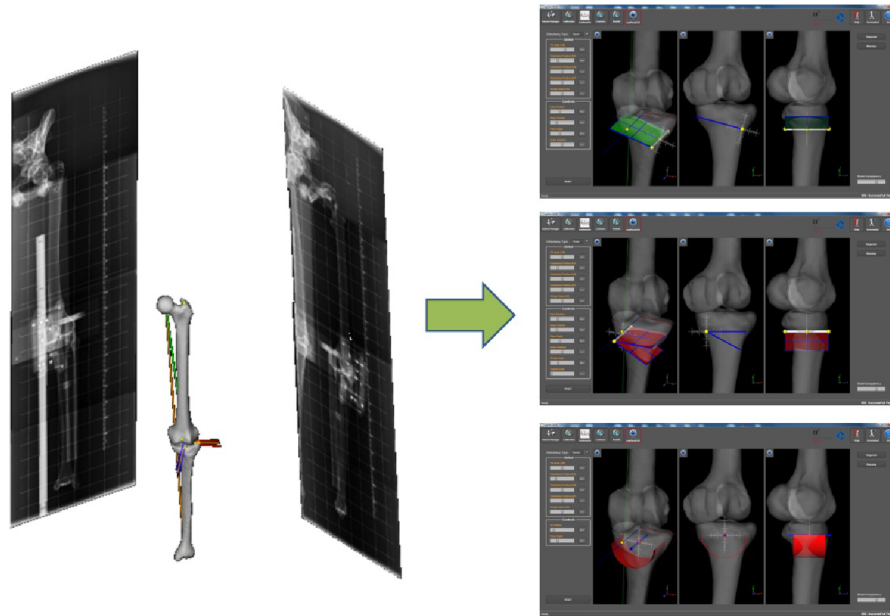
Reconstructed bone models within the calibrated space of original radiographs (*left*) with a screenshot of the preoperative planning software based on the models (*right*). Retrieved from [2].
